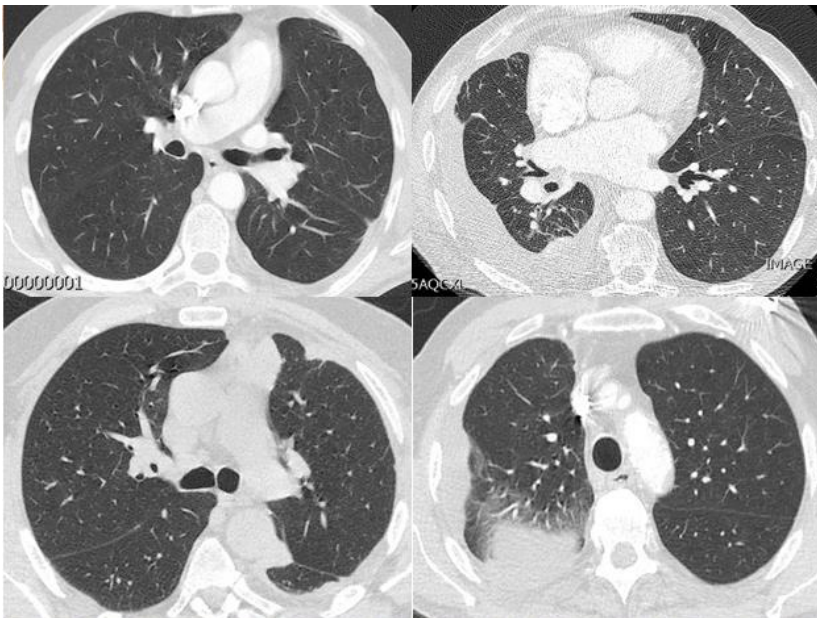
Thoracic CT scans of patients demonstrating the similar appearances of benign pleural disease (upper images) and mesothelioma (lower images).
